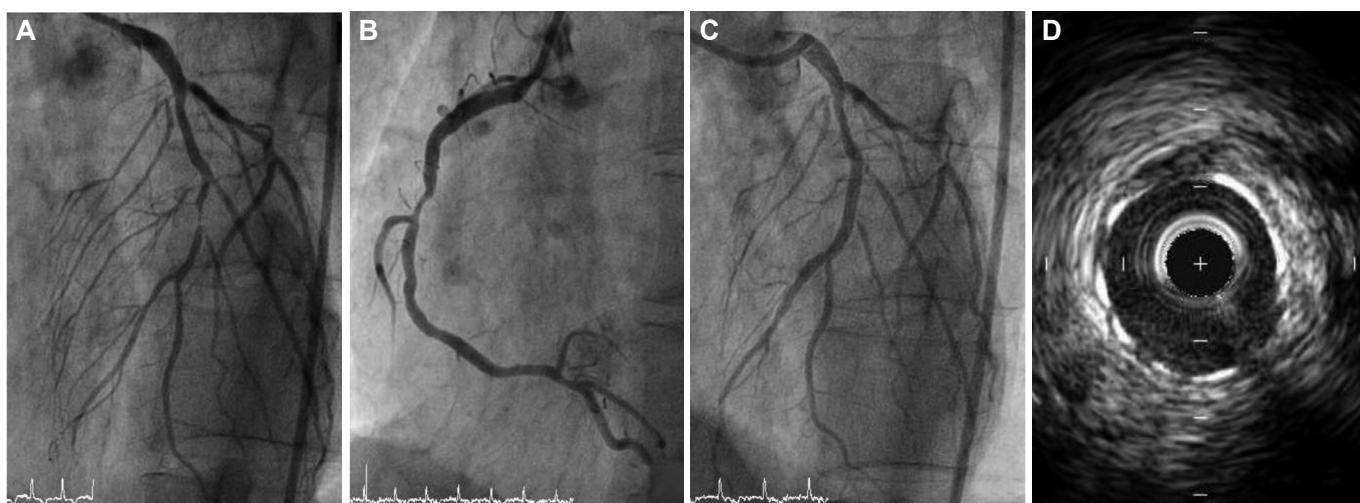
Initial coronary angiography. A: left coronary angiography shows near total occlusion of the mid left anterior descending coronary artery and intermediate stenosis of the left circumflex coronary artery. B: right coronary artery shows significant stenosis at the mid portion. C: after stent implantation, coronary angiography shows a successful result. D: final intravascular ultrasound finding after overlapping stent does not show dissection, or stent malapposition, or stent underexpansion.
